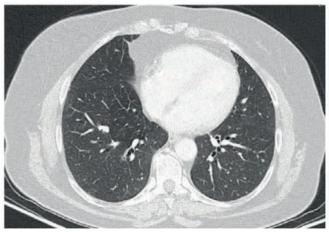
Chest computed tomography showed multiple small nodules in the pulmonary parenchyma.
